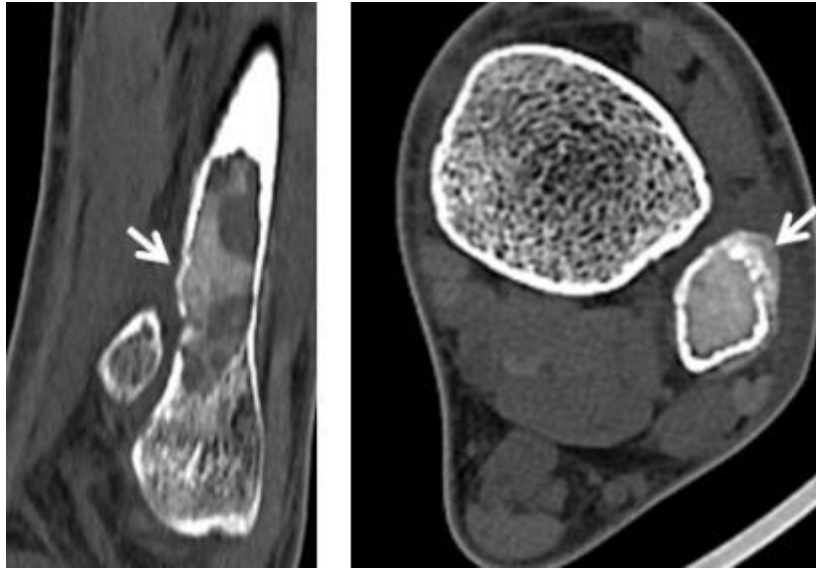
Oblique sagittal and axial CT showing bone mineralization of the right fibula one month after the adenoma resection
